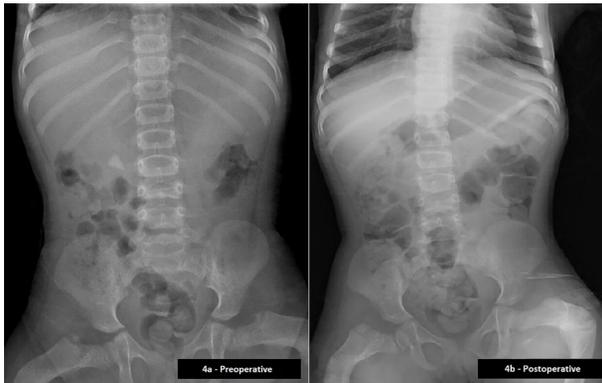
Preoperative (4a) and Postoperative Third Month (4b) X-ray Image
